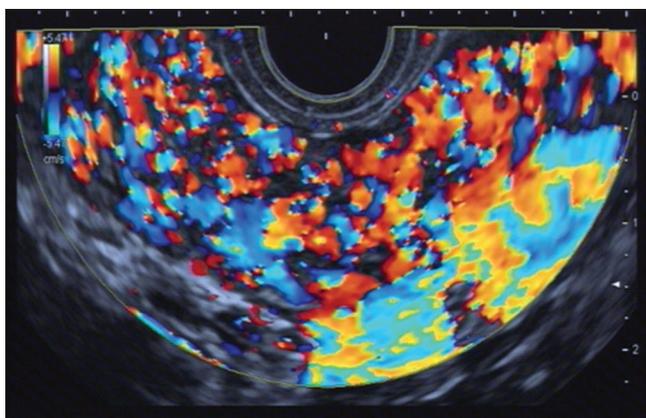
Diffuse autoimmune pancreatitis using radial endoscopic ultrasound (color Doppler). Note the homogeneously hypervascular pancreatic parenchyma
